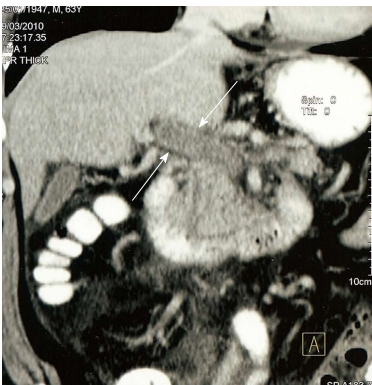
Coronal reconstruction of contrast-enhanced computed tomography image with arrows indicating portal venous thrombosis and evidence of cavernous transformation.
